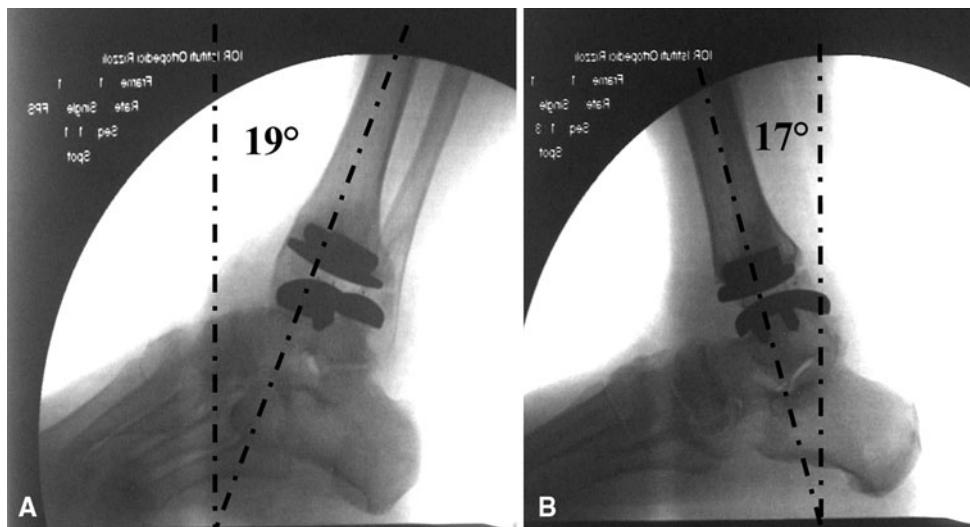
Fluoroscopic radiographs were taken at the 48-month followup with the patient in double-leg stance, with the ankle in maximum (A) plantar flexion and (B) maximum dorsiflexion, the latter achieved by maintaining the foot in the same plantigrade position on the floor and advancing the contralateral leg as much as
